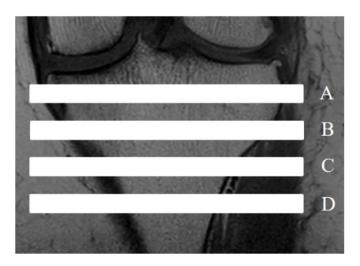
Configuration of zone A (5–10 mm distal from lateral tibial plateau), zone B (15–20 mm distal), zone C (25–30 mm distal), and zone D (35–40 mm distal) are shown in the coronal view of the MRI.
